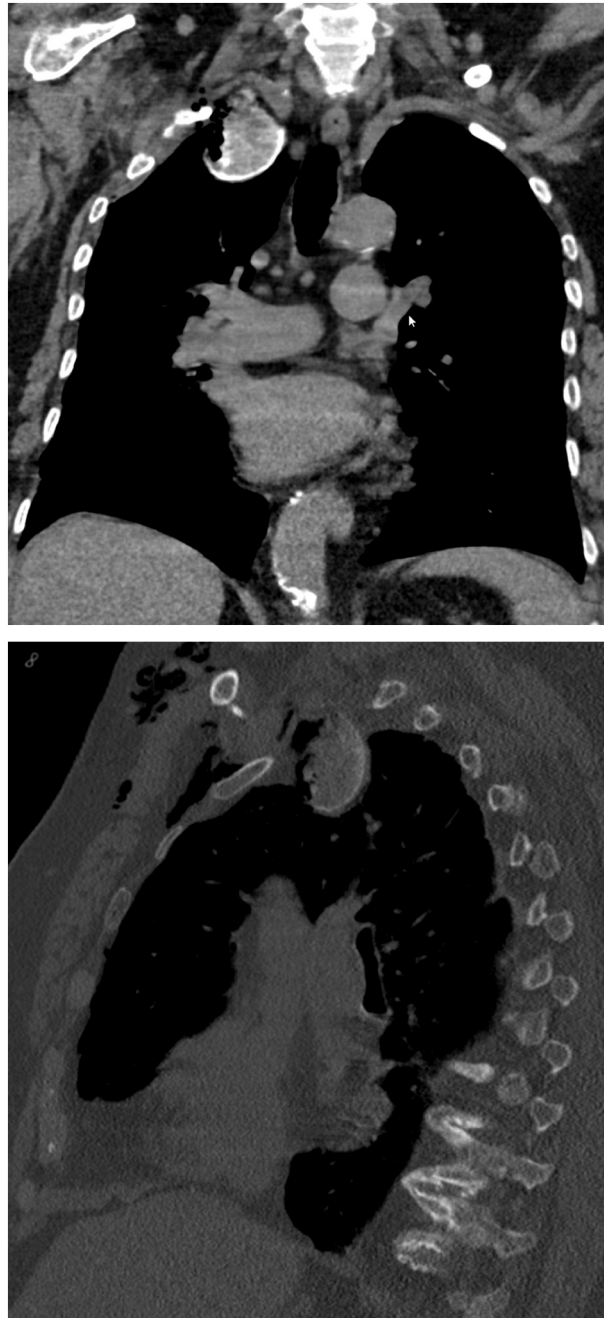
CT-scan showing an intrathoracic humeral head fragment on the right apex.
